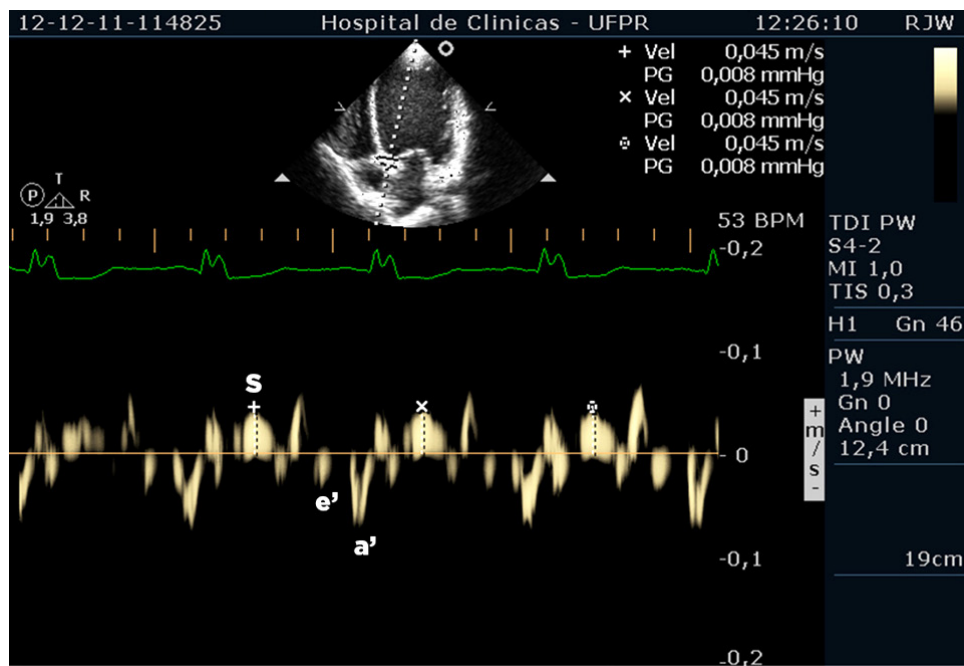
Tissue Doppler with the sample volume positioned in the mitral valve ring plane, in the septal wall S: systolic wave; e': early diastolic wave; a': atrial systolic wave.
